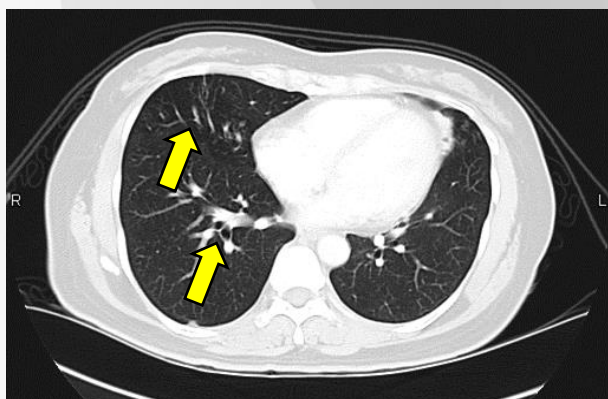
A chest CT scan (2004) showing tree-in-bud sign (arrows)
